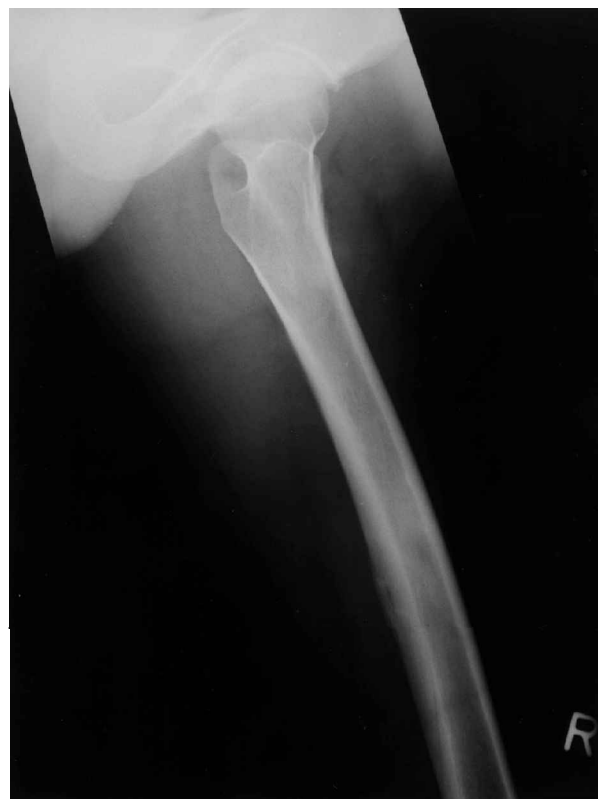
Conventional radiograph of the femur shows generalized periosteal thickening with an area of bulging periosteum and a slight hypodense region within it. A soft tissue component is noted.
